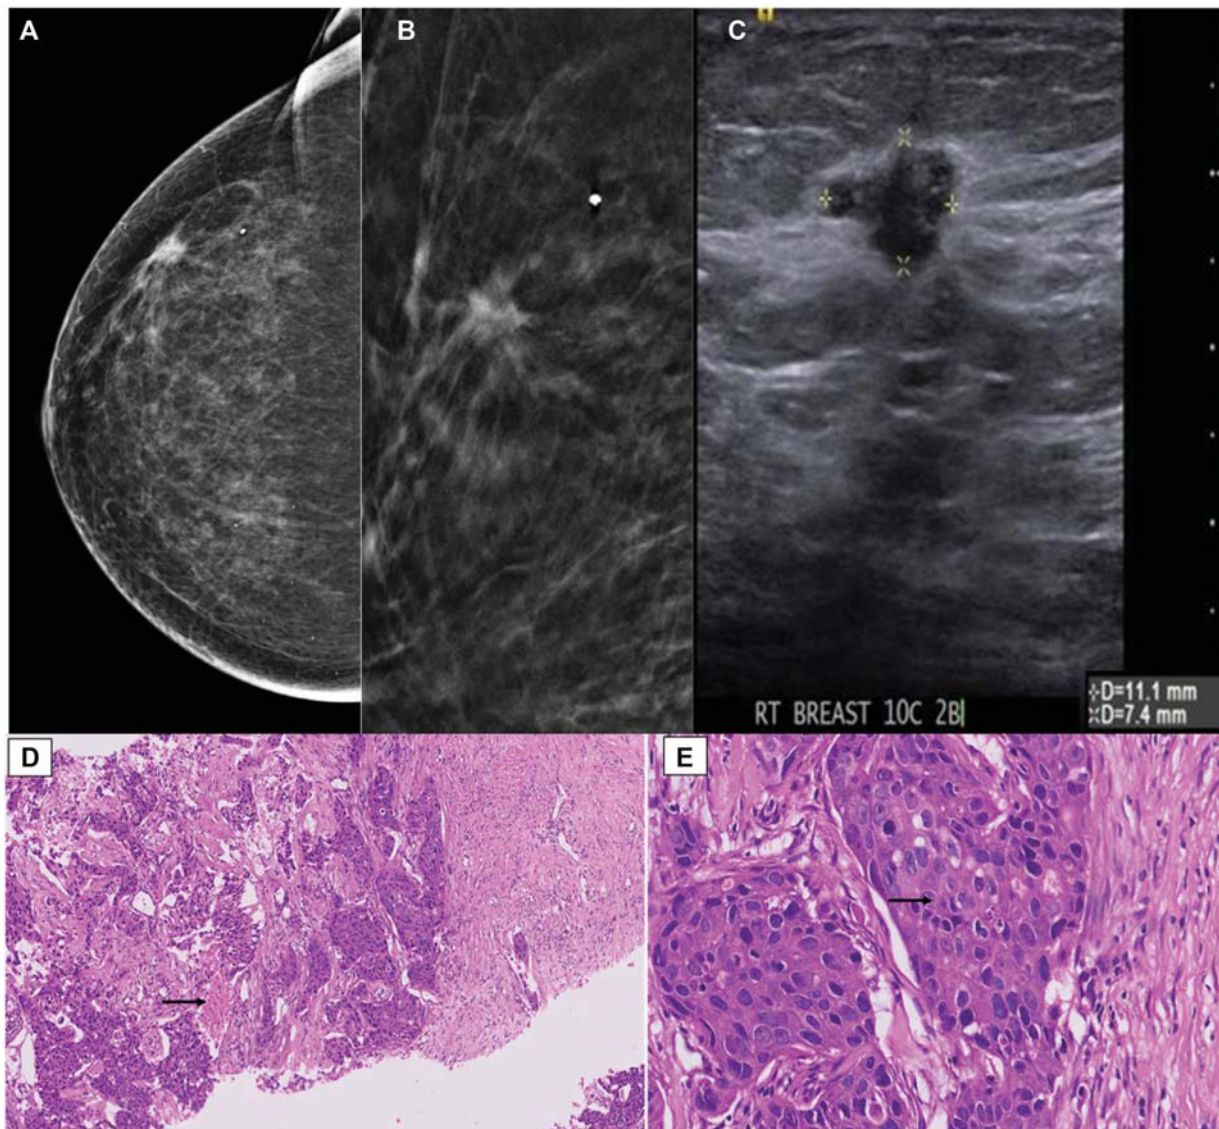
A 78-year-old female came for routine screening with a family history of carcinoma breast. Mammogram (A, B) showing an irregular spiculated high-density lesion in the upper outer quadrant of the left breast. The Sonogram (C) showed an irregular microlobulated hypoechoic lesion. A Core needle biopsy was taken and corresponding pathological image (D) shows nests of invasive breast carcinoma, grade 3 with intermixed areas of necrosis (arrow), and image (E) shows cells showing marked nuclear atypia and prominent nucleoli (arrow).
